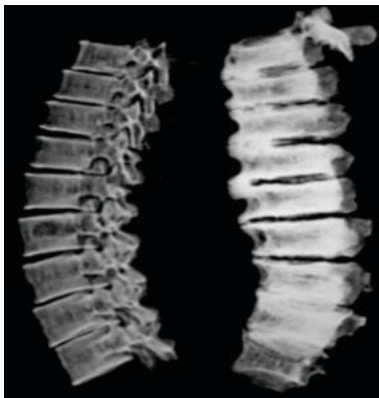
Shows the Radiographic Image of Skeletal Fluorosis
